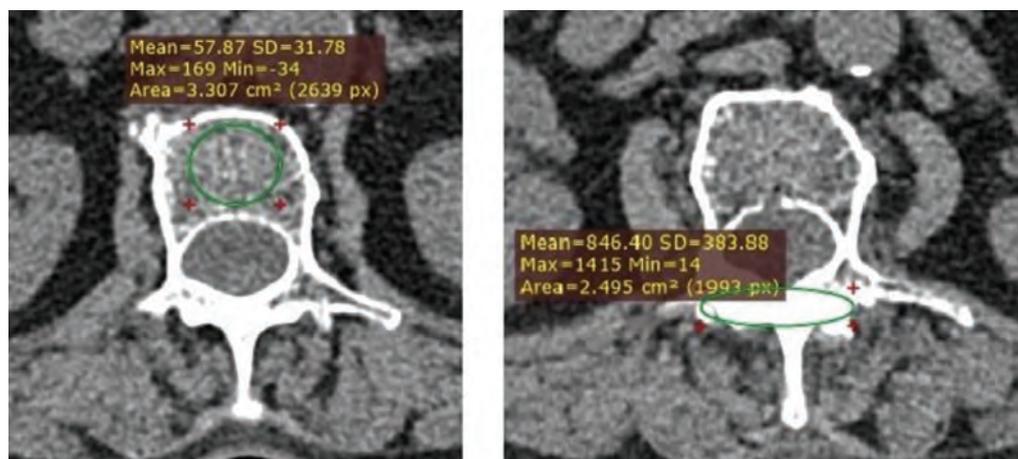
CT scan assessment of cancellous bone density (left) and cortical bone in the pars interarticularis region (right) of the L1 vertebra.
